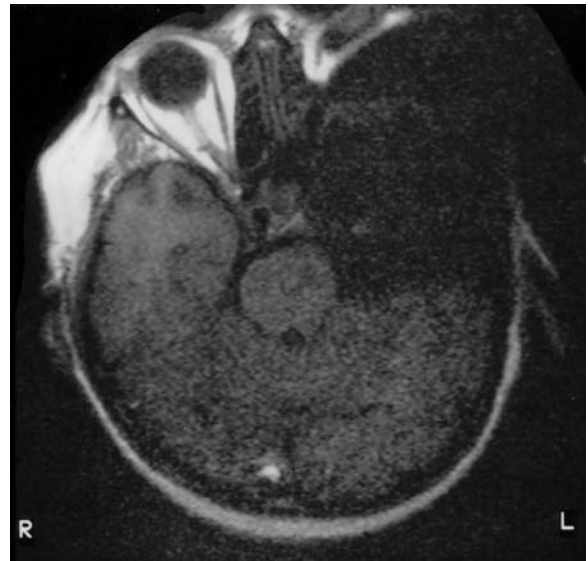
Axial localizer of MRI, demonstrating the deformed loss of signal at the left orbit, caused by a fixed shell splinter in the left maxillary bone
